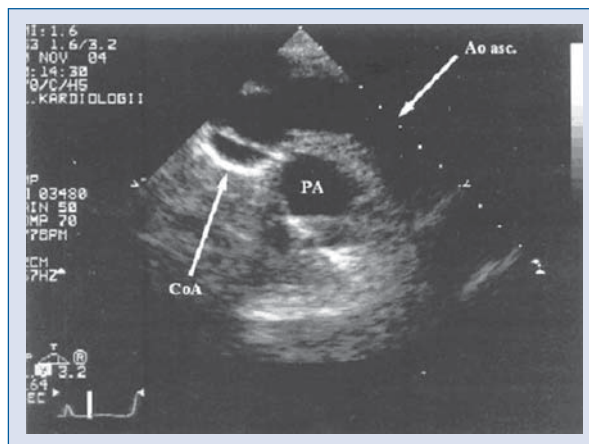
Aortic arch in echocardiography (jugular incisure projection); CoA — coarctation of aorta; Ao asc. — ascending aorta; PA — pulmonary artery.
